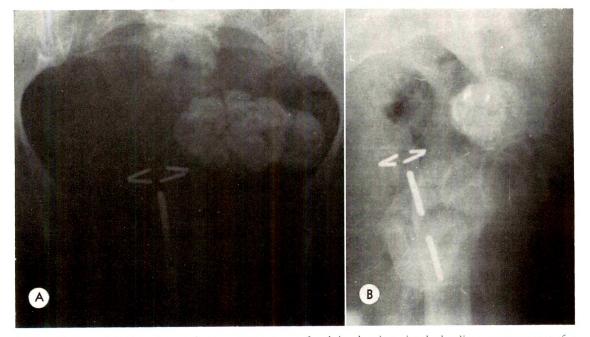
Case i. (A) Anteroposterior roentgenogram of pelvis showing simple loading arrangement for prophylactic irradiation of vaginal vault. (B) Lateral view.
